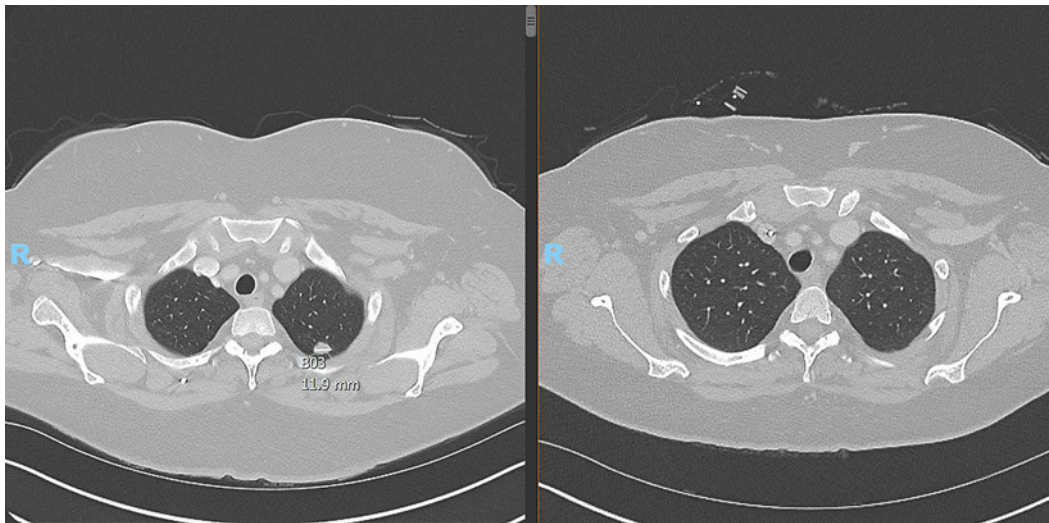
Single transverse section of a CT chest scan demonstrating complete response; the patient has no evidence of disease to date.
